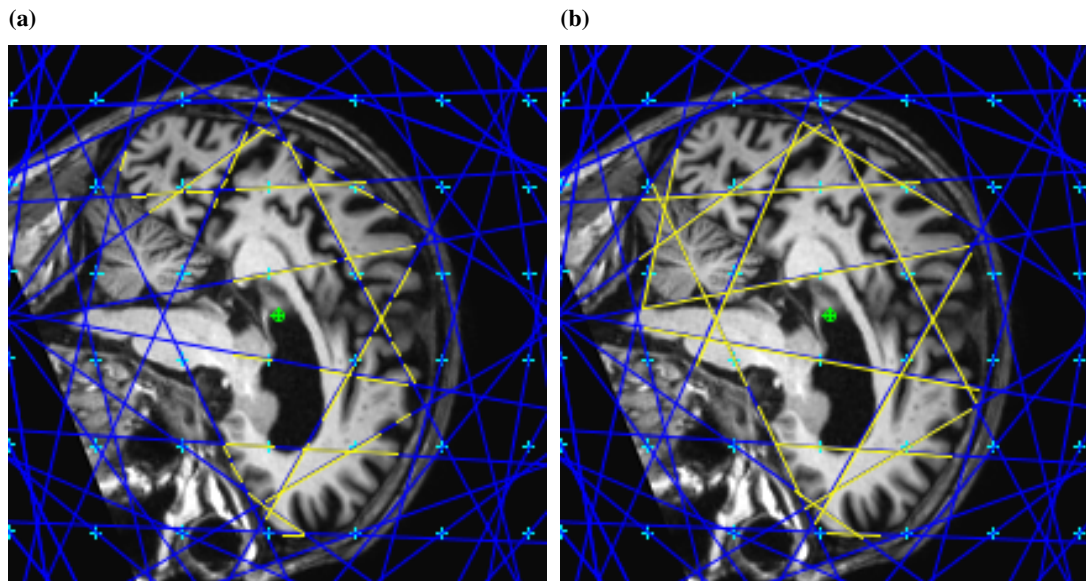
Estimation of (a) cerebral and (b) intra-cranial volumes by the INV method on one IR rotated section plane of one AD brain MR image.
